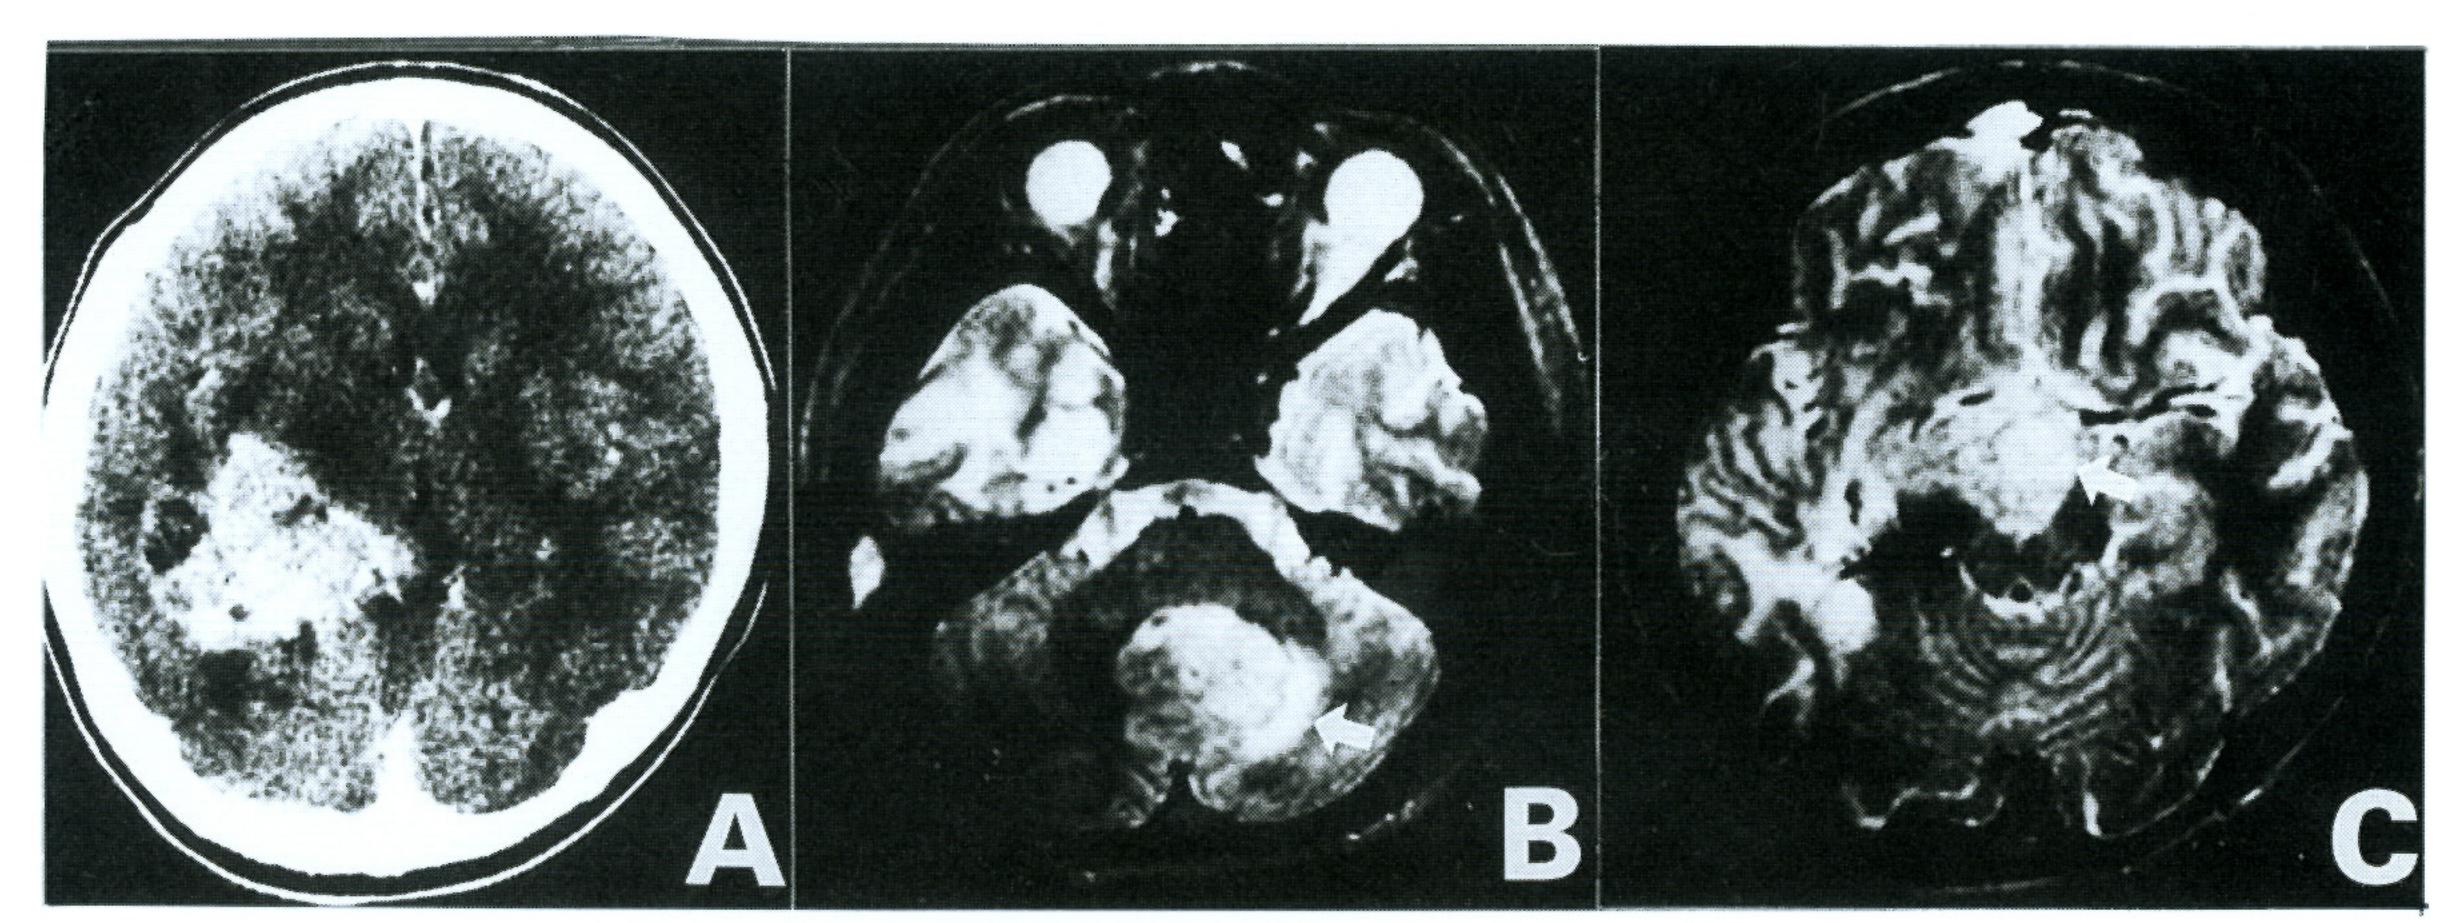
Preoperative CT scan and post-regrowth MRI of case 2.
